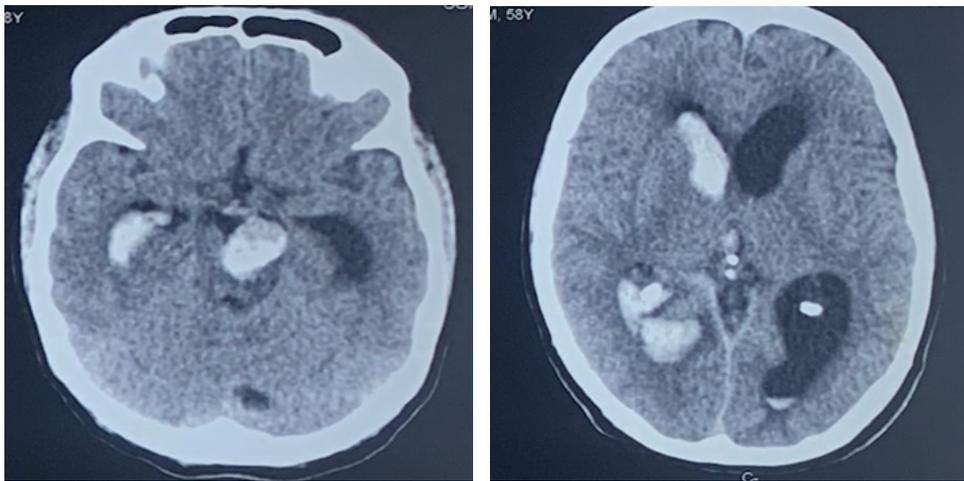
Head Computed Tomography, axial views. (a): Mesencephalic hematoma with dilatation of temporal horns with hematoma. (b): Hydrocephalus in lateral ventricles with hemorrhage.
